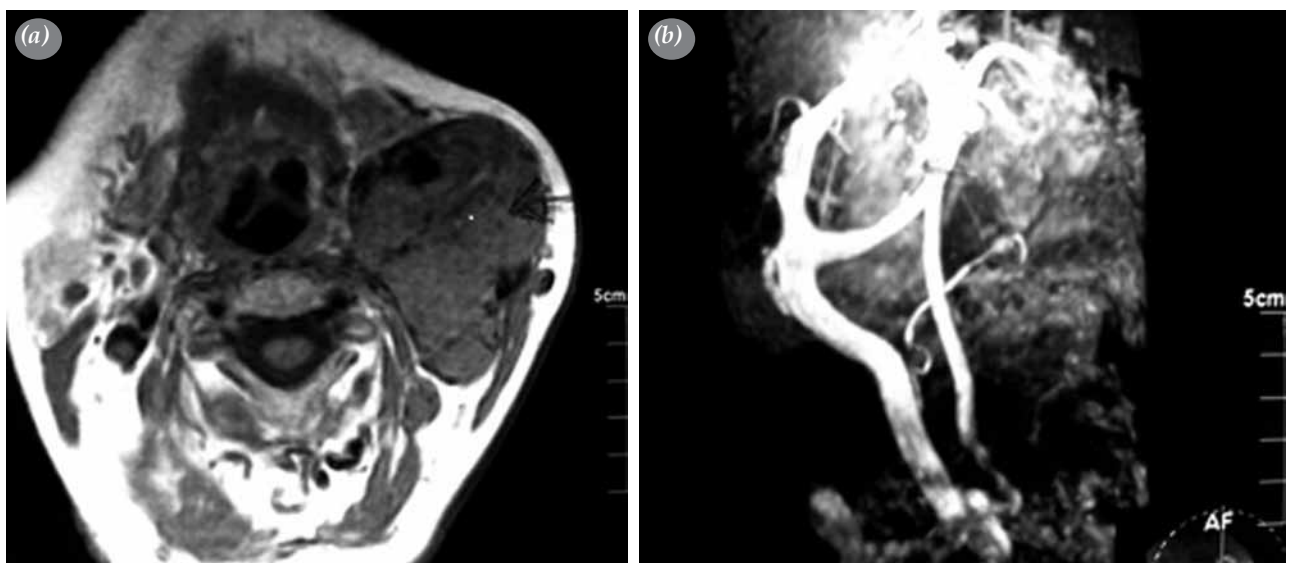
(a) Computed tomography scan showing the left carotid body tumor. (b) Preoperative magnetic resonance imaging of the same patient.
